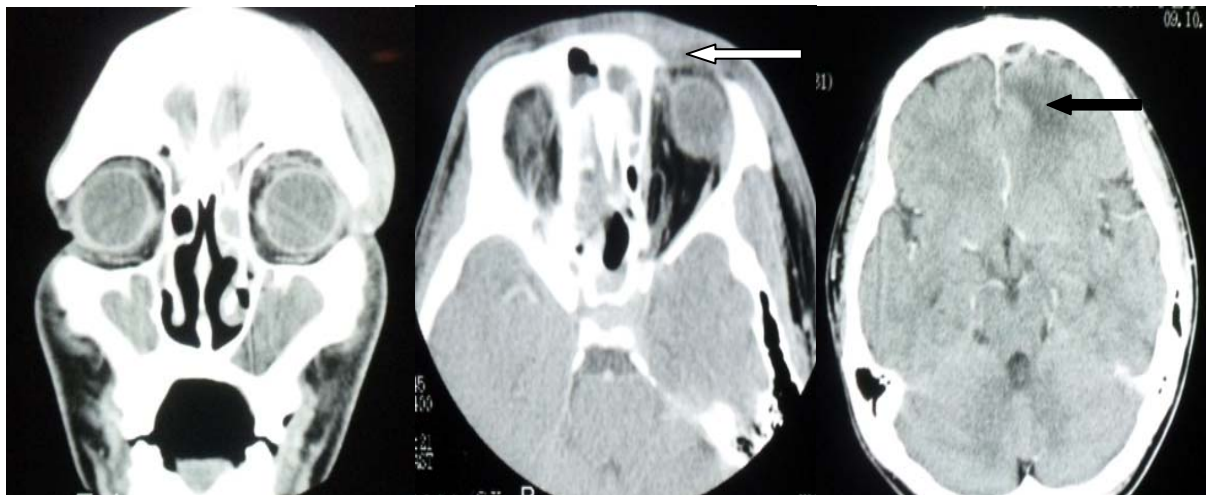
Coronal and axial CT showing left frontal and ethmoid sinusitis with left supraorbital cellulitis (white arrow) complicated with left frontal extraaxial collection and frontal cerebritis (black arrow).
